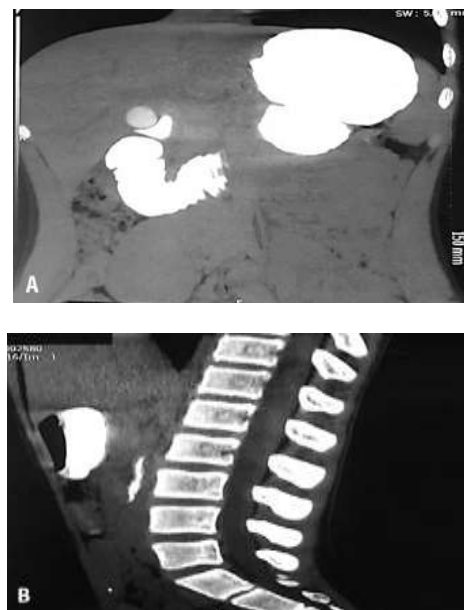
CT-Enteroclysis: Frontal view showing an obstructed PC D3 level (1-A), Sagittal view showing a narrowing of the third portion of duodenum (1-B)
